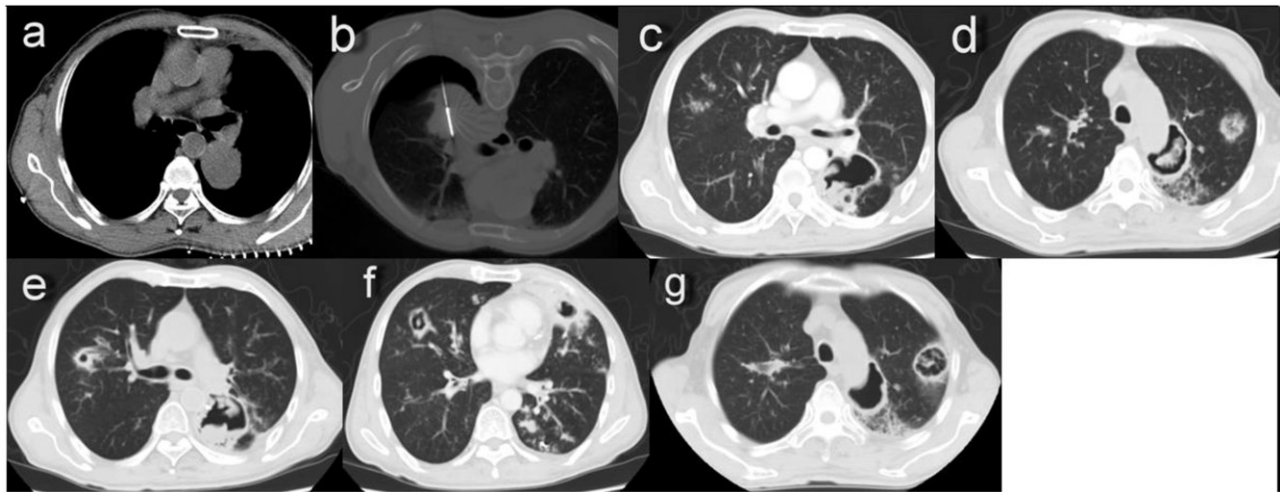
(a) A chest CT image showing a primary tumor 4.5 cm in diameter abutting the thoracic aorta and left lower pulmonary artery in the superior segment of the left lower lobe. (b) Despite a mild pneumothorax, MWA was successfully completed with a power of 70 W for a total of 21 min. (c) A CT scan 3 weeks after MWA showing a thin-walled cavity with an irregular luminal surface in the ablation zone. (d) The same CT scan 3 weeks after MWA showing coexistence of the cavity and nodules with a halo sign in the left upper lobe. (e) The same CT scan 3 weeks after MWA showing consolidation with cavitation in the right upper lobe and an uneven thin-walled cavity containing pedunculated contents in the left lower lobe. (f) A CT scan 5 weeks after MWA showing diffuse consolidations with cavitation, infiltrations and nodules in bilateral lungs. (g) The CT scan 5 weeks after MWA showing the cavity emptying inside, as well as nodules enlarged and cavitated in the left upper lobe.
